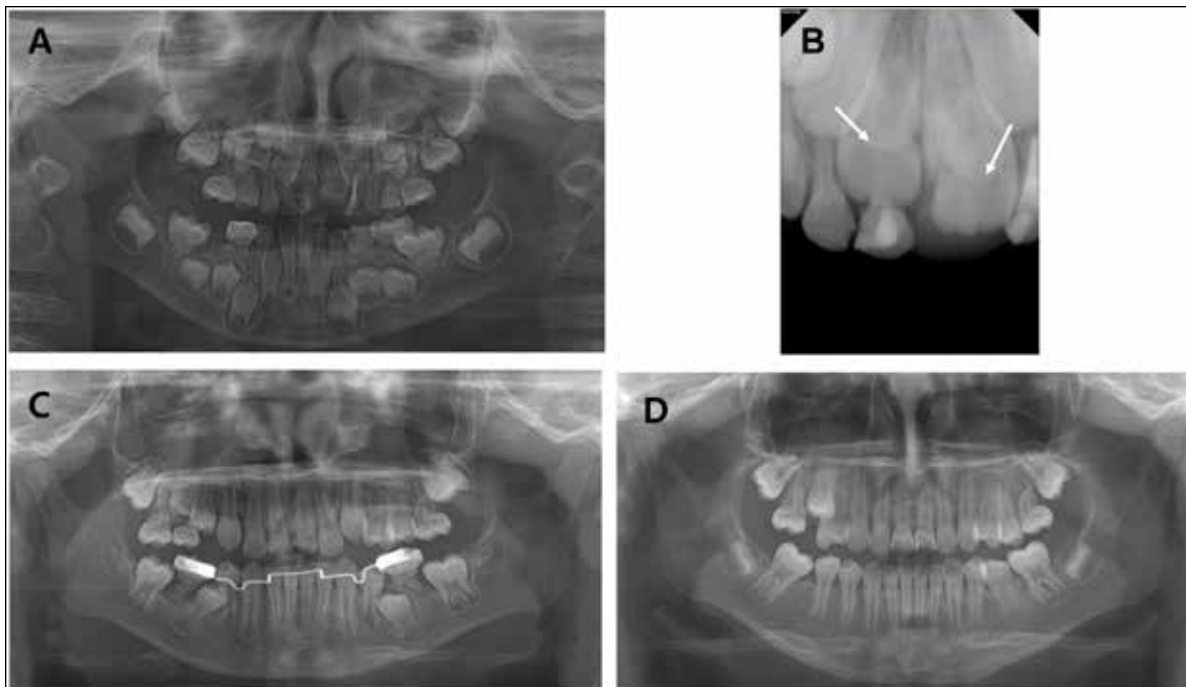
Case 1. (A) Panoramic radiograph and (B) periapical radiograph of a seven-year-old boy with MRIM at the first visit. The bilateral permanent maxillary central incisors had a notch-shaped defect on the crown (white arrow). (C) Three years and nine months later, a panoramic radiograph was taken before the extraction of the symptomatic mandibular first molar. (D) One year and three months after the extraction, space closure was accomplished.
